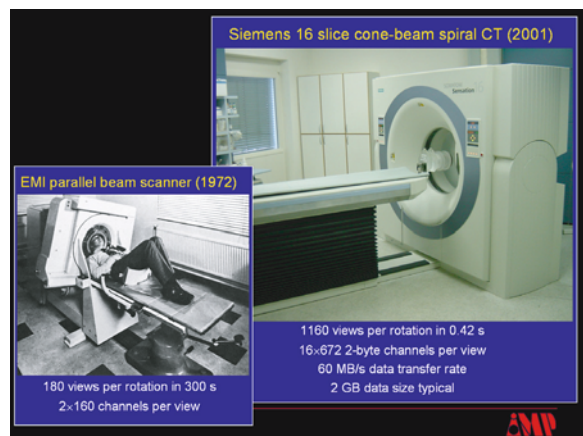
Subsecond true 3D cone-beam scanner with submillimeter resolution
